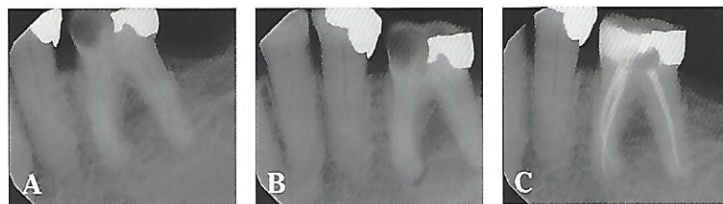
(A) Periapical radiograph taken centered at 90° on a lower molar with percussion sensitivity and spontaneous pain. (B) Periapical radiograph taken at the same time but with an approximately 10° mesial angle. Periapical changes now evident. (C) Periapical radiograph taken 6 months after endodontic therapy with a similar angle, indicating periapical healing. (Images courtesy of Dr. Asgeir Sigurdsson.)
